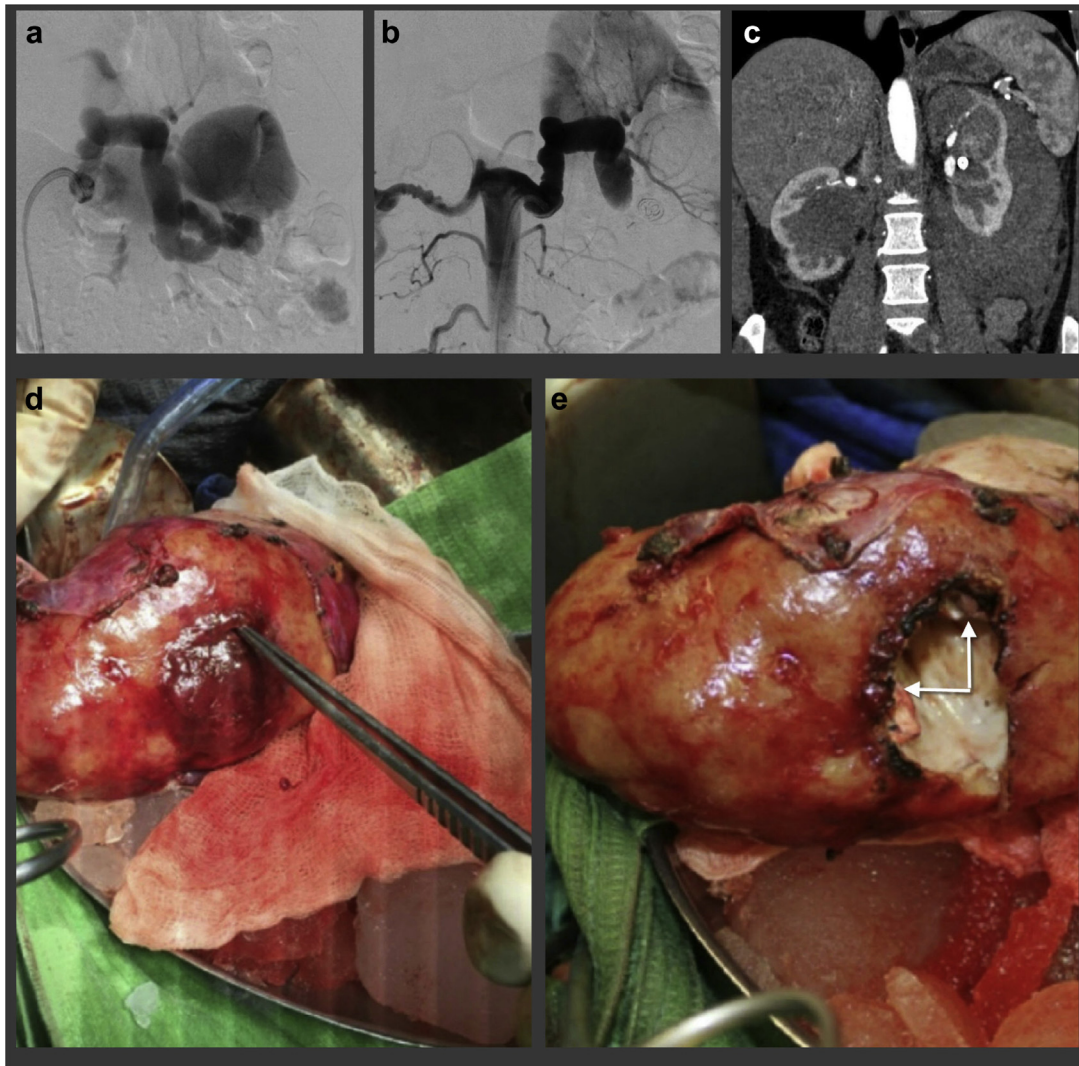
Digital subtraction angiography, computed tomography (CT), and intraoperative images of the left renal arteriovenous fistula (AVF). Left renal angiogram before (a) and after (b) coil embolization shows occlusion of fistula. c, CT angiography (coronal reformation) shows a perinephric hematoma. d, Intraoperative picture. The left kidney is placed in the tray with ice cubes. The tip of forceps inserted in the ruptured renal aneurysm. (e) Intraoperative image. The oversewn orifices of feeding and draining arteries with patches (*arrows*).
